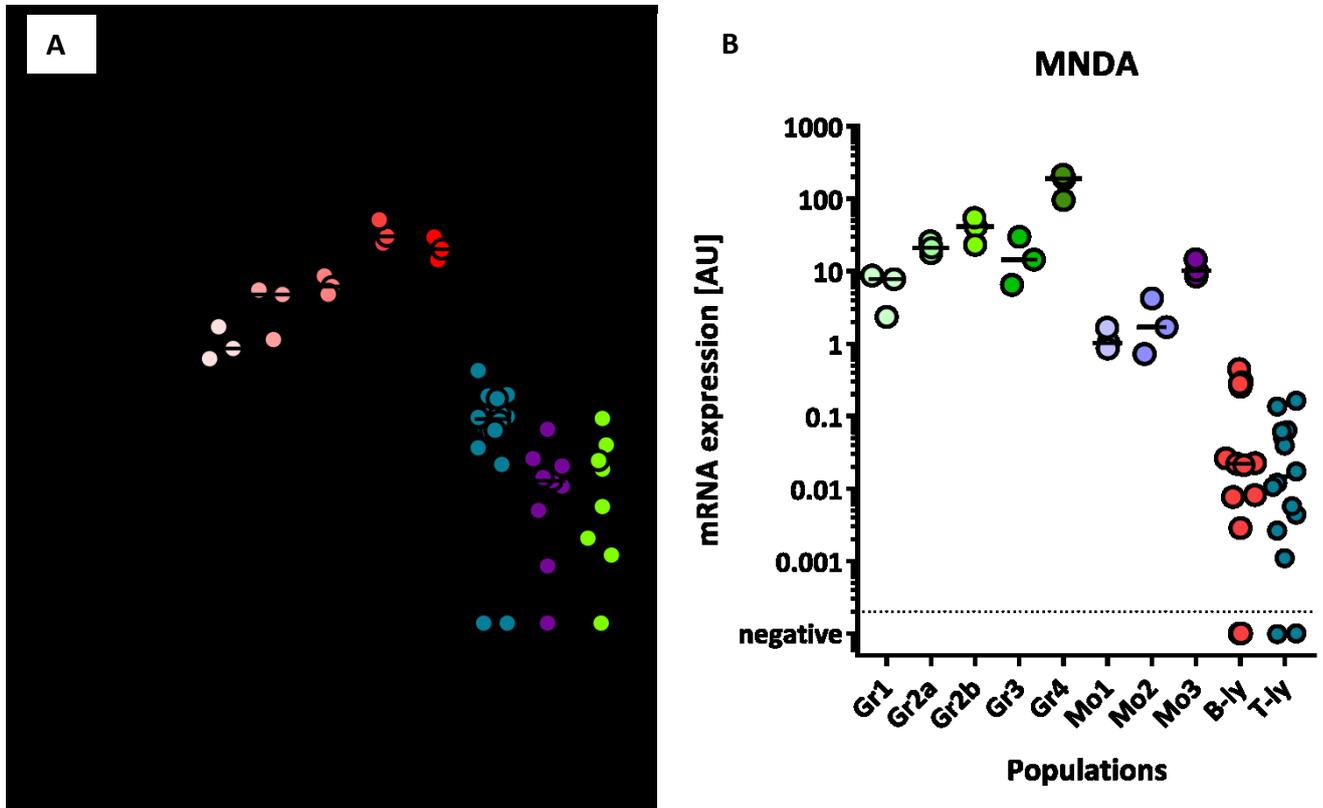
Expression of (A) *POU2AF1* in B-lymphocytes (B-ly) during B-cell development and its comparison with other lineages; and (B) *MND A* during granulocyte (Gra) and monocyte (Mo) development in comparison with B- and T-lymphocytes (B- and T-ly); data are presented as $2^{-\Delta CT}$; samples with undetectable expression are marked as negative; horizontal lines represent medians.
